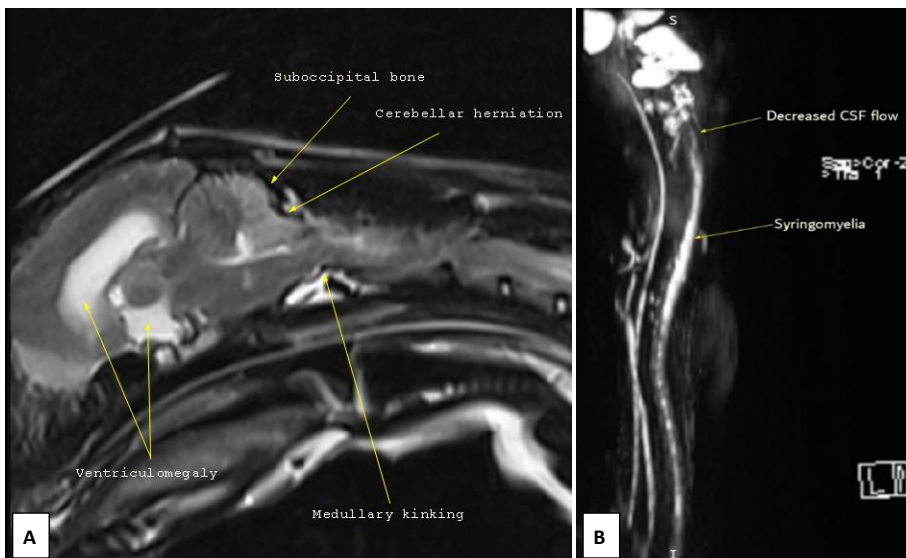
Chiari malformation findings on T2-weighted sagittal imaging (A), HASTE sequence showing syringomyelia (B).
